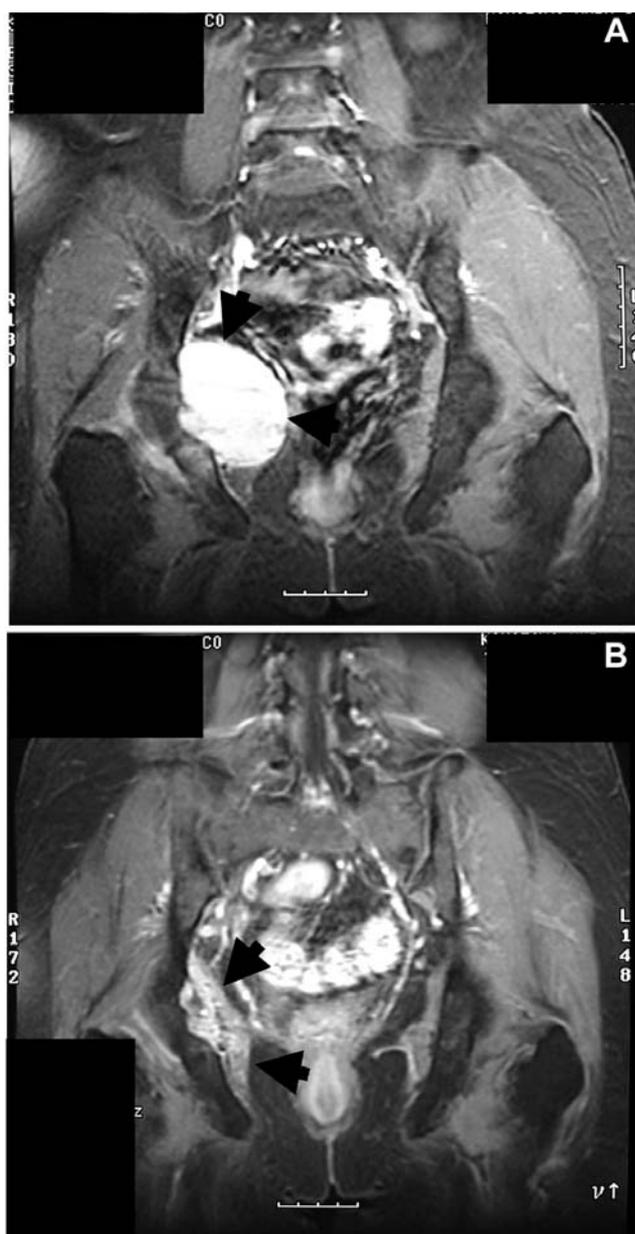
MRI findings before and after chemotherapy. A. Bone tumor of the acetabulum with a large soft tissue mass. B. Marked tumor shrinkage after five courses of chemotherapy. Arrows indicate the soft tissue mass.
